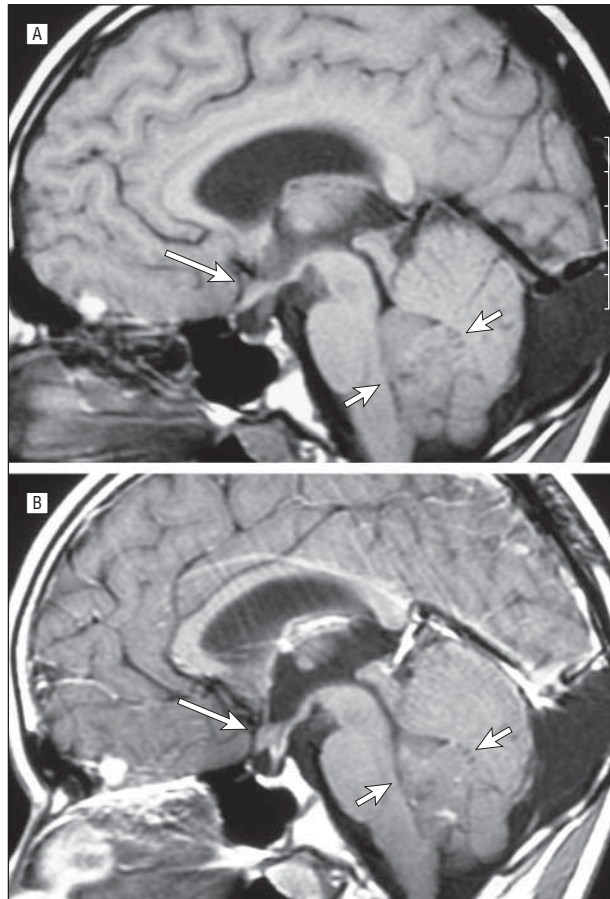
Sagittal T1-weighted images without contrast medium (A) and with contrast medium (B) in a child with a medulloblastoma. The tumor fills the fourth ventricle and shows minimal, punctuate enhancement (B). A nonenhancing metastasis is present in the infundibular recess of the third ventricle, causing abnormal thickening behind the chiasm. Arrows show the nonenhancing tumor and the infundibular metastasis.
